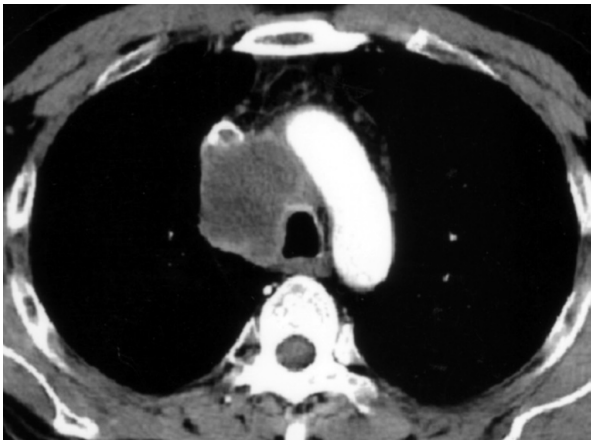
(b). Middle mediastinal mass causing nearly total occlusion of the superior vena cava with suspected tracheal wall invasion in the chest CT.
